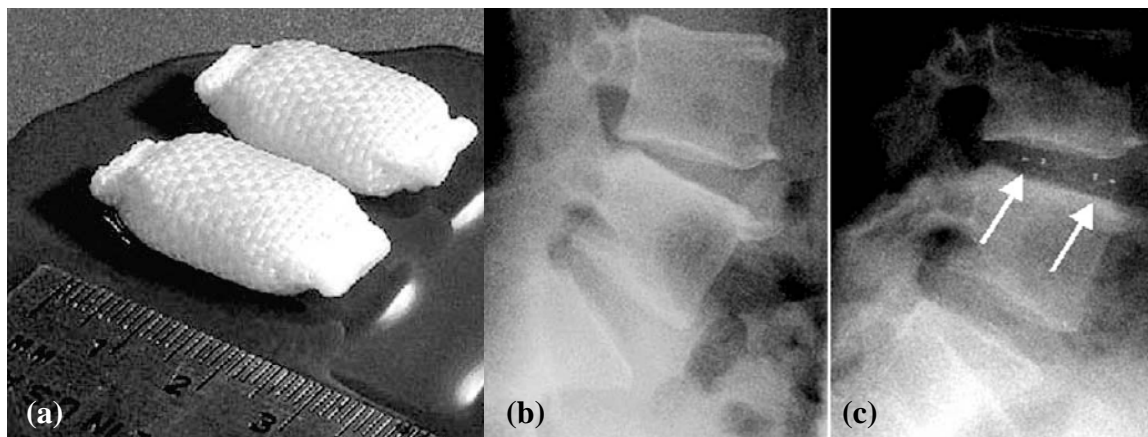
(a) Example of a nucleus prosthesis, the PDN artificial device, (b) preoperative lateral radiographic view with degenerative disc disease on L4-L5, (c) postoperative lateral radiographic view [59]
